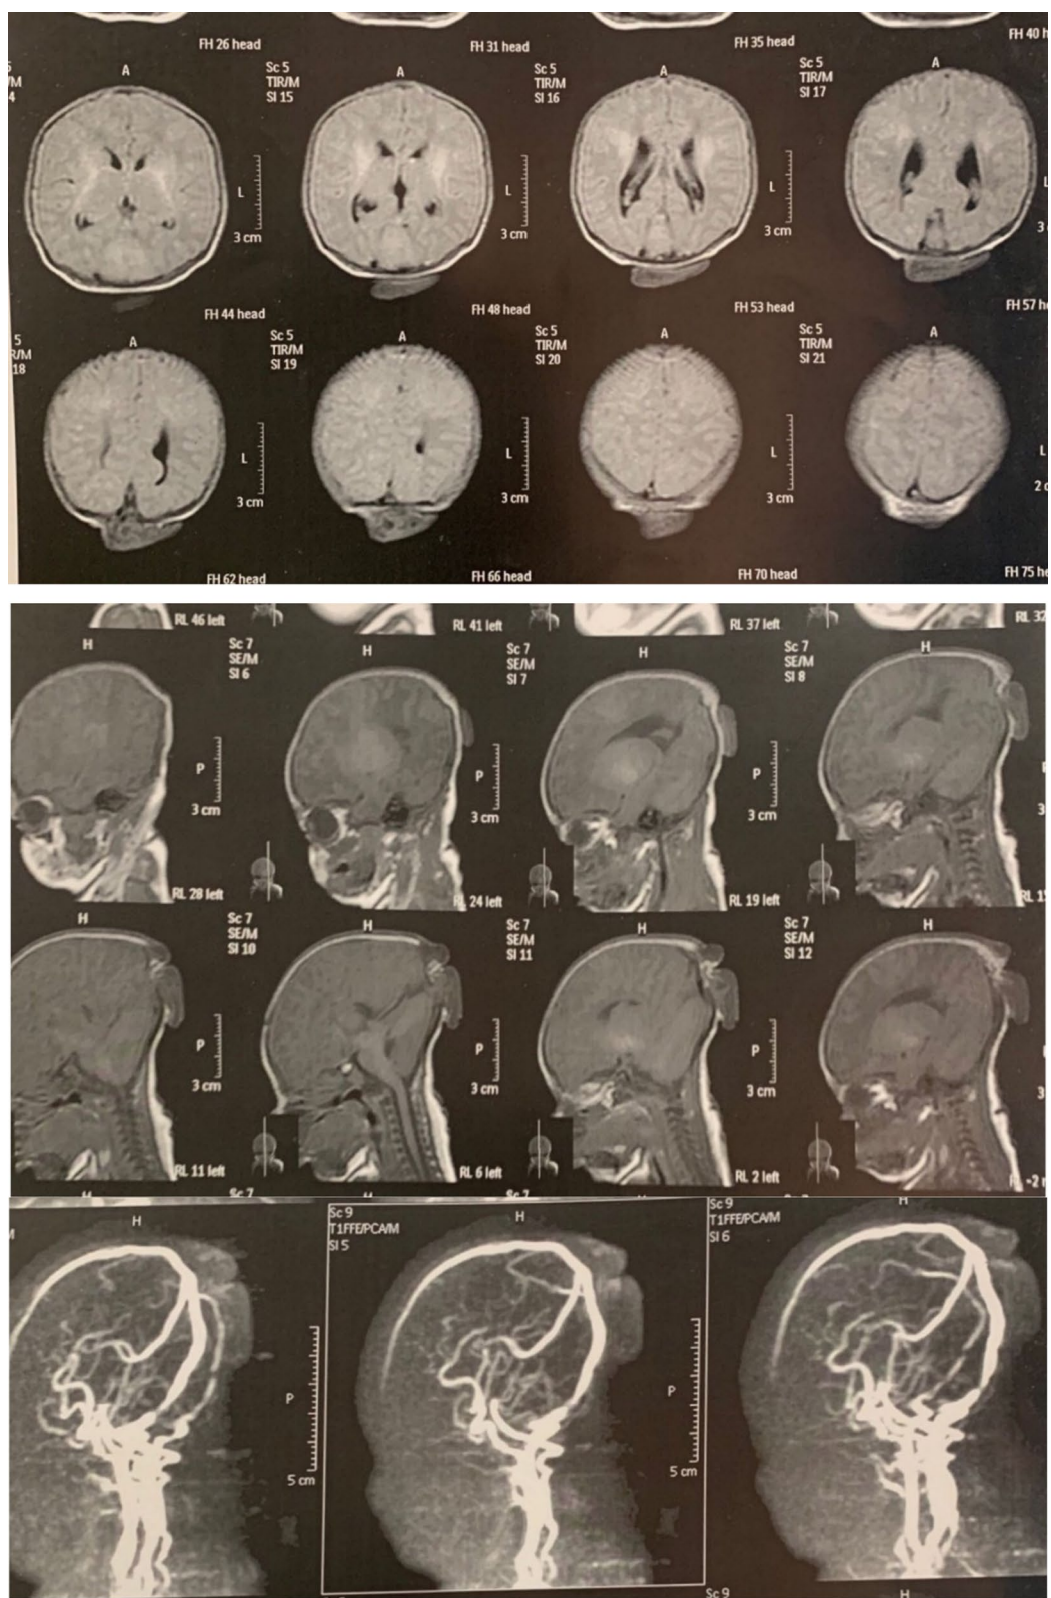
CT brain, MRI brain and MRV of our case
